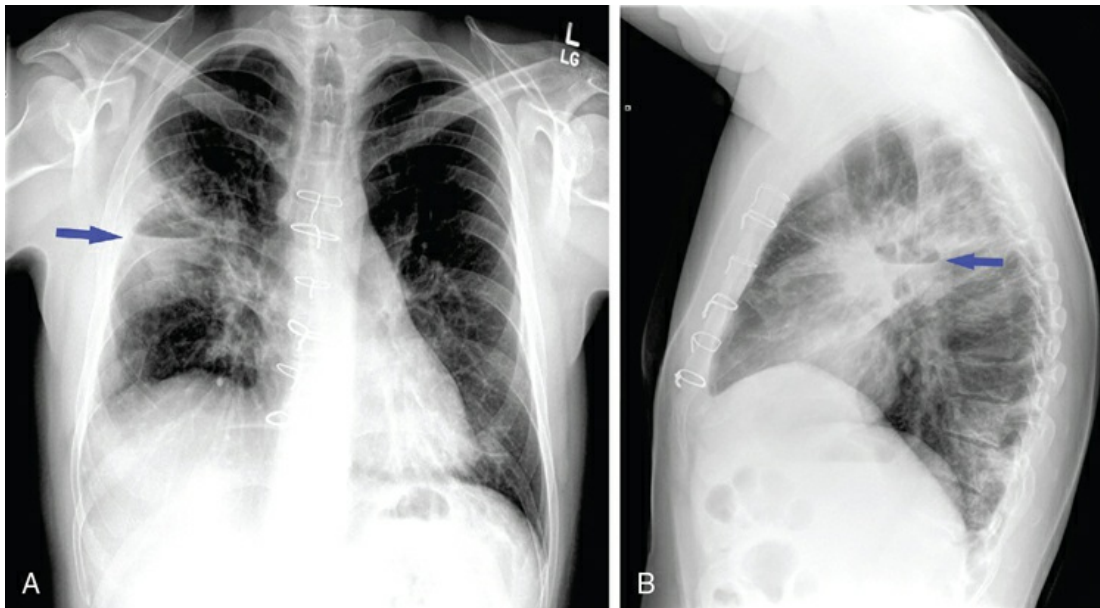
Posteroanterior (A) and lateral (B) chest radiographs showing a cavitary lung abscess with an air-fluid level (arrows) in the right upper lobe. Note the sternal wires. The patient had a history of intravenous drug use and had undergone tricuspid valve surgery for endocarditis. *Source:* (Courtesy of Dr. Laura Avery.)
